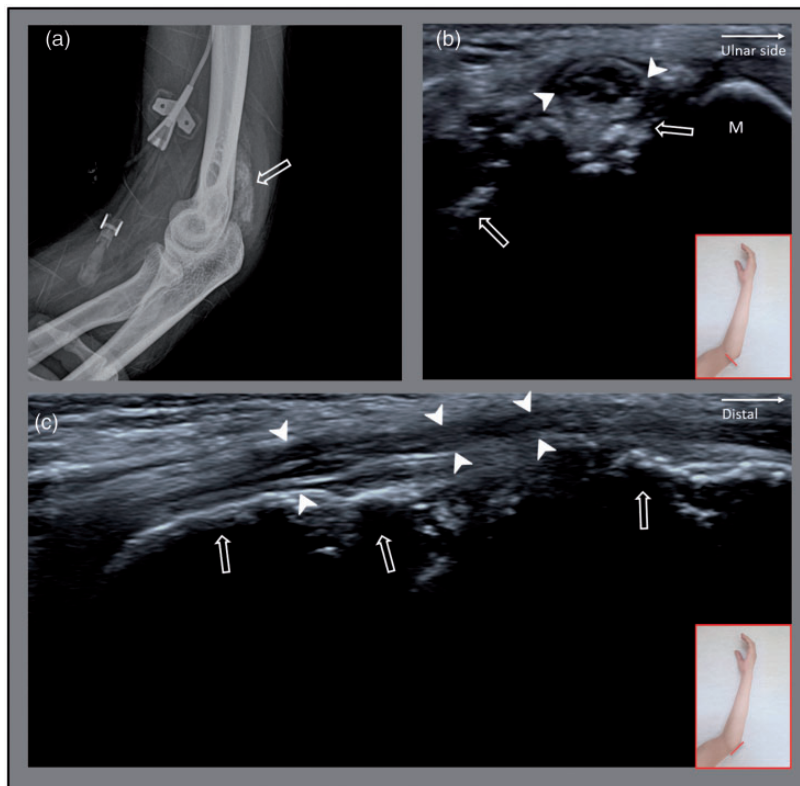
(a) Lateral radiograph of the left elbow showed a 0.9- × 4.4-cm calcification (open arrow) proximal to the olecranon on the posterior aspect of the distal humerus. (b) Transverse ultrasound revealed an edematous, enlarged, hypoechoic ulnar nerve (arrowheads) above the myositis ossificans (MO) (open arrows) and outward displacement of the ulnar nerve caused by the MO. (c) Longitudinal ultrasound revealed 0.9- × 1.8- × 4.5-cm MO (open arrows) around the left triceps, which had a hypoechoic center surrounded by a hyperechoic peripheral area. The edematous, enlarged, hypoechoic ulnar nerve (arrowheads) was also observed above the MO. M, medial epicondyle.
